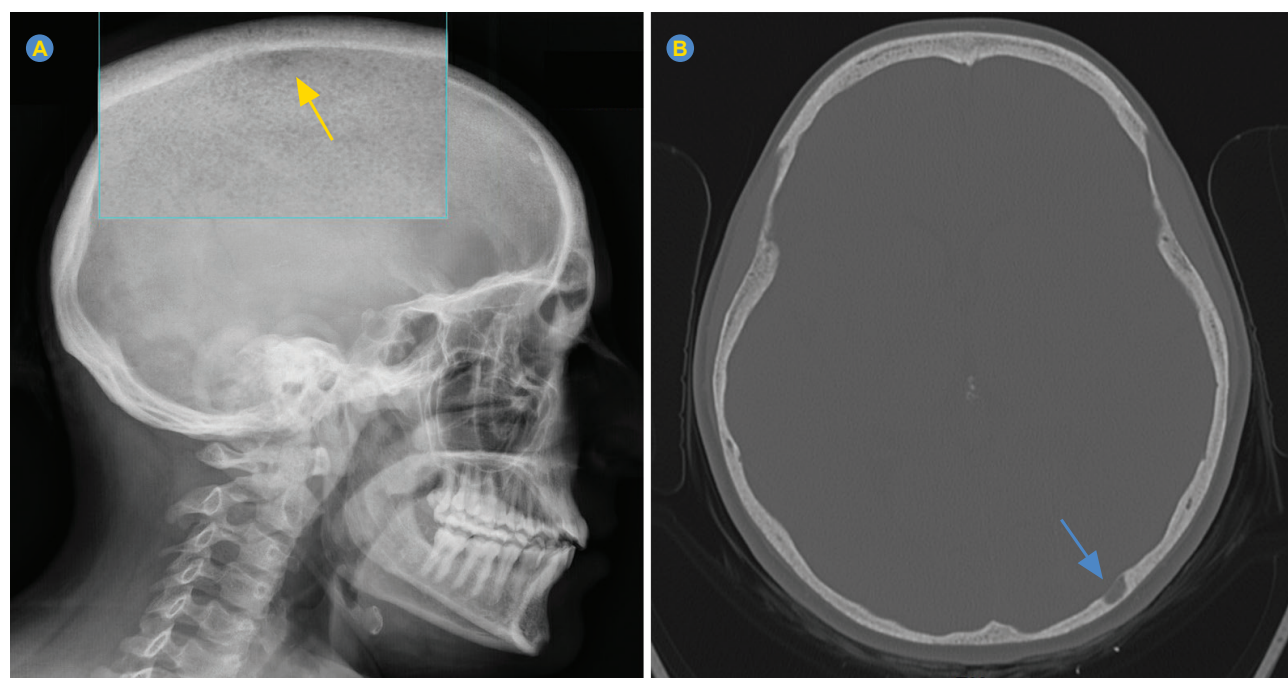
(A) Head x-ray (yellow arrow – salt-and-pepper pattern) and (B) head CT (blue arrow – brown tumor)
